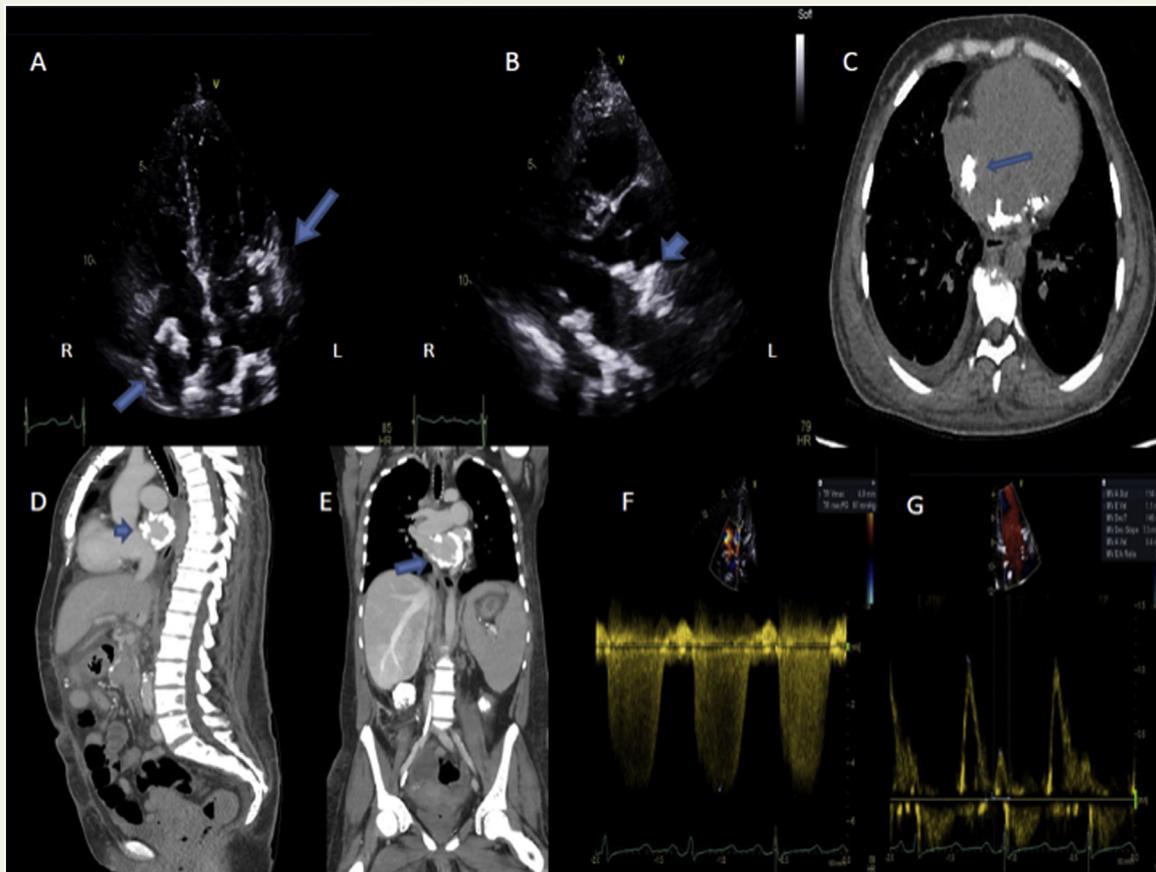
Apical four chamber (A) and parasternal long-axis (B) echocardiography views of biatrial and left atrial calcification respectively. Axial (C), sagittal (D) and coronal (E) computed tomography views of biatrial calcification. Tricuspid regurgitant jet velocity (F) and left ventricular in-flow velocity (G) demonstrating elevated pulmonary systolic pressures and filling pressures, respectively.
